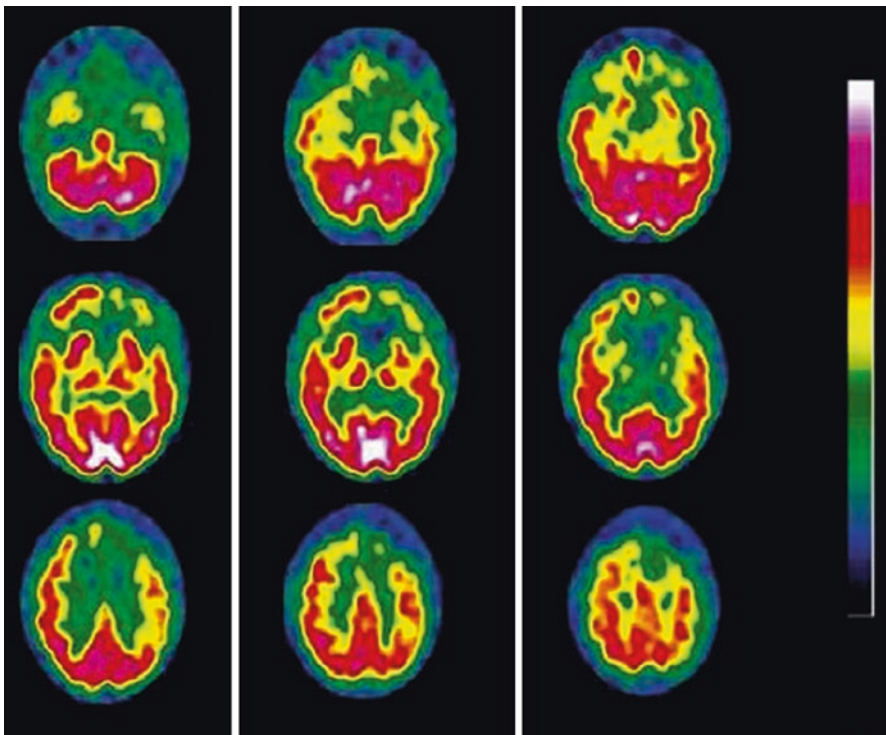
Single-headed HMPAO SPECT study of a patient suffering from frontotemporal dementia. Transaxial slices from *bottom* to *top*. Moderate to severe cortical hypoperfusion of the frontal lobes, especially on the *left*, and slight hypoperfusion of the temporal poles
